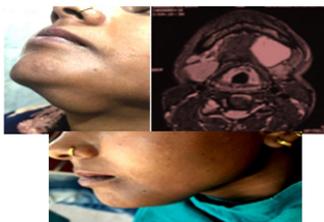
Figure (a) showing a pre-op clinical picture of haemangioma in the submandibular region (b) MRI showing a vascular mass displacing anterior belly of digastric and mylohyoid (c) Post-treatment result showing complete resolution of the lesion with sodium tetradecyl sulphate.
